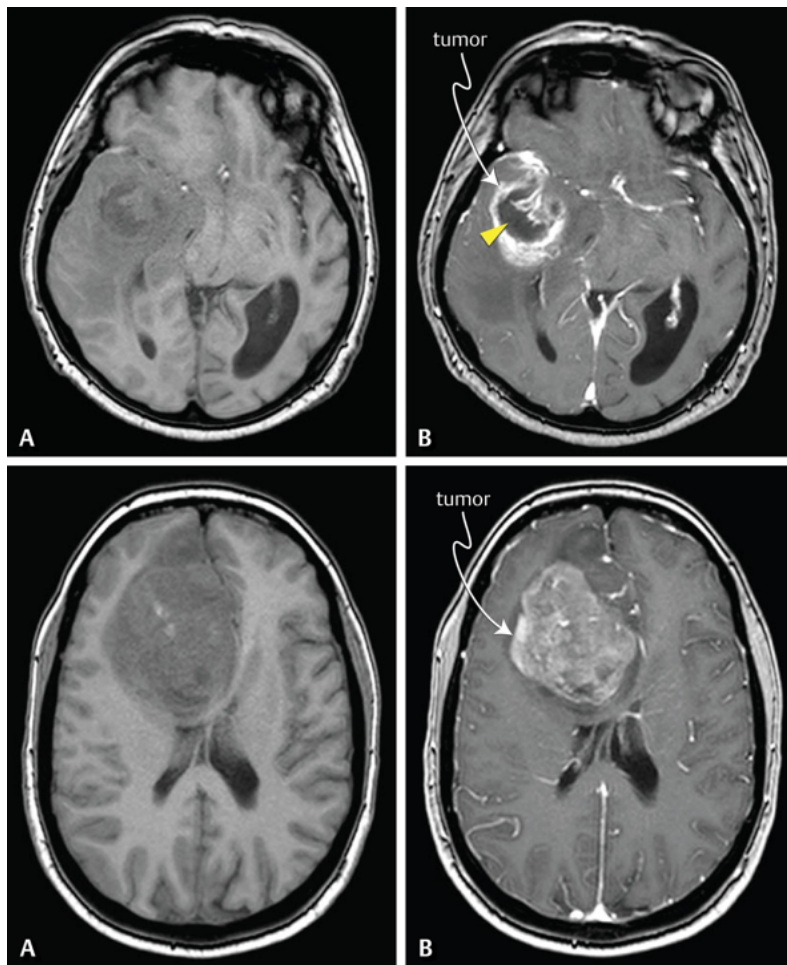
Axial glioblastoma T1 (A) and T1C (B) MR scans [43]. *Upper row:* Primary GBM with molecular signature IDH-wildtype (95 % of cases). Most often found in the temporal lobe, these tumors are characterized by extensive edema with a central necrosis (yellow arrowhead) and hyperintensities on the contrast-enhanced T1-weighted image (right). *Lower row:* Secondary GBM of type IDH-mutant without dark necrotic area.
